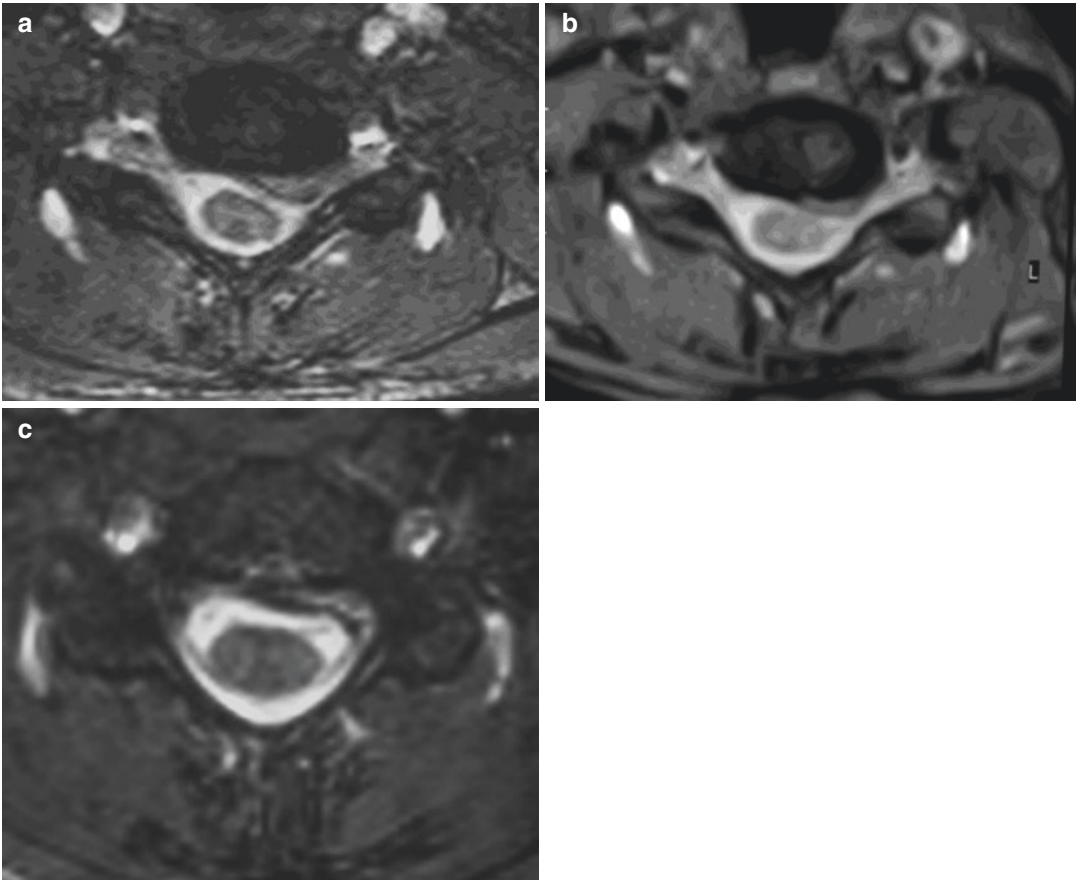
(a) Magnetic resonance imaging at baseline for a 34-year-old female patient who underwent percutaneous plasma radiofrequency-based discectomy for a disk (C6–C7) herniation compressing the spinal cord and causing clinical signs of myelopathy. (b) A 7-week MR follow-up
